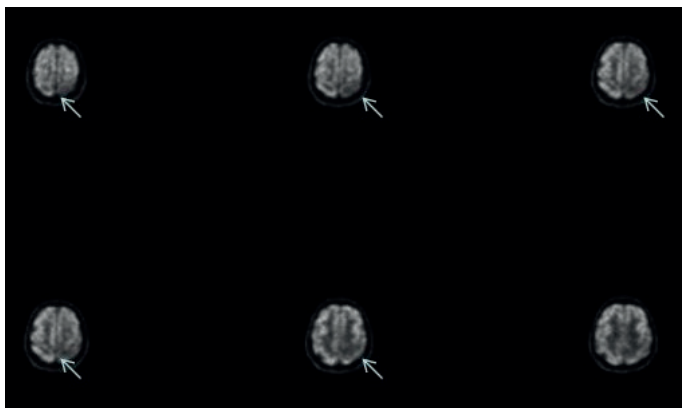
FDG-PET, brain images demonstrates decreased cerebral metabolic rate for glucose of left posterior parietal region (arrows).
